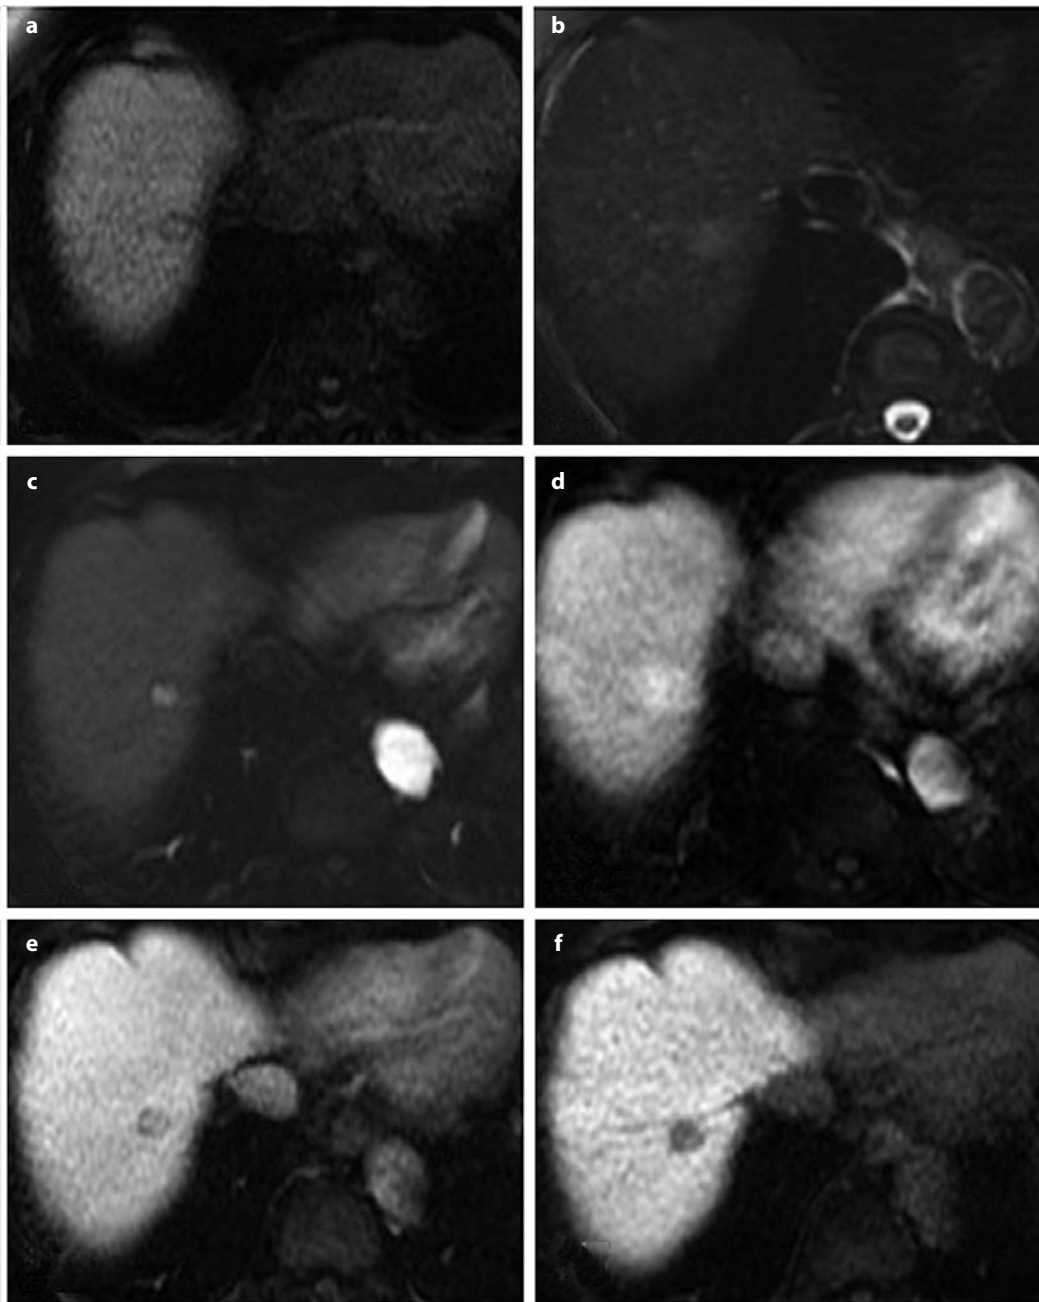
a-f. Typical hepatocellular carcinoma (HCC) in a 77-year-old woman with chronic hepatitis C virus (HCV) infection. At magnetic resonance imaging (MRI), a baseline T1-weighted imaging (WI) shows the presence of a hypointense nodule of segment VII, which appears clearly hyperintense on b T2-WI. After gadolinium ethoxybenzyl diethylenetriamine pentaacetic acid (Gd-EOB-DTPA) administration, the nodule shows washin during the c early arterial phase that persists during the d parenchymal arterial phase and clear washout on the e delayed phase. f On hepatobiliary acquisition, the lesion appears hypointense because of complete loss of biliary activity of de-differentiated hepatocytes
